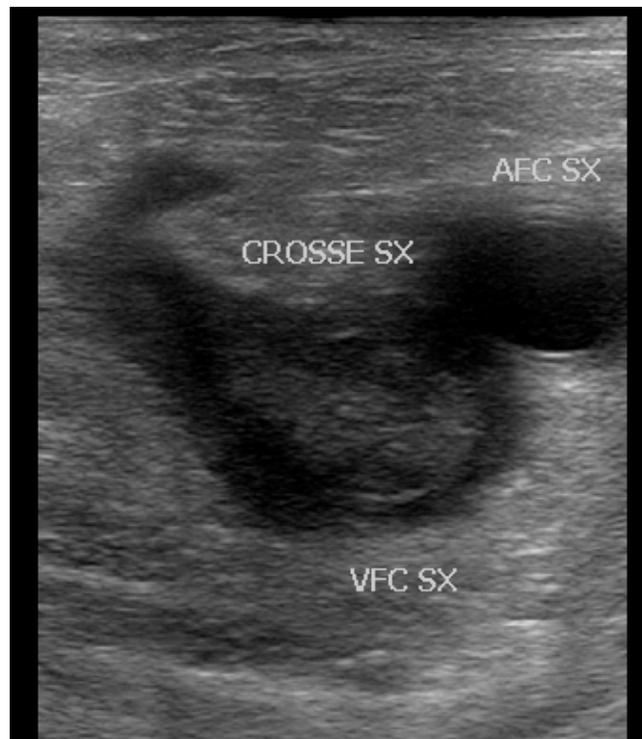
Echocolor Doppler with CUS in left femoral vein DVT.
